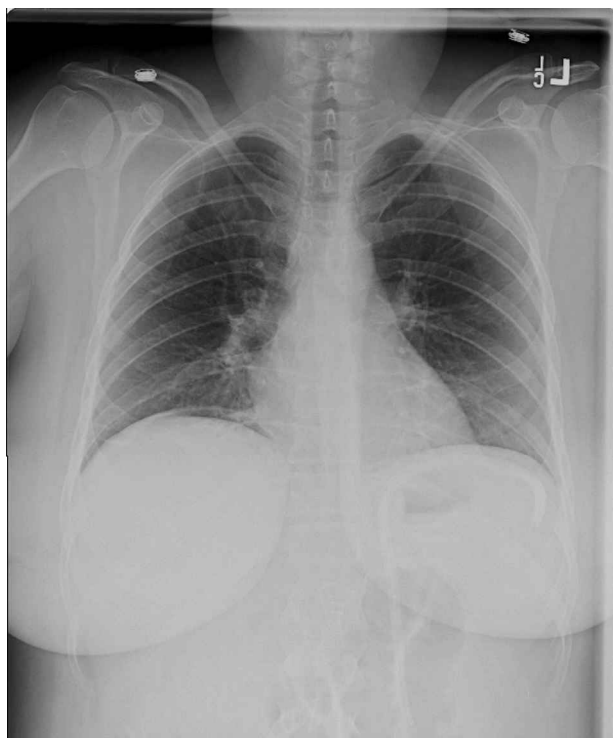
Free air on upright chest x-ray. Note that the air could still be unabsorbed CO₂ from the laparoscopic gastric bypass.
